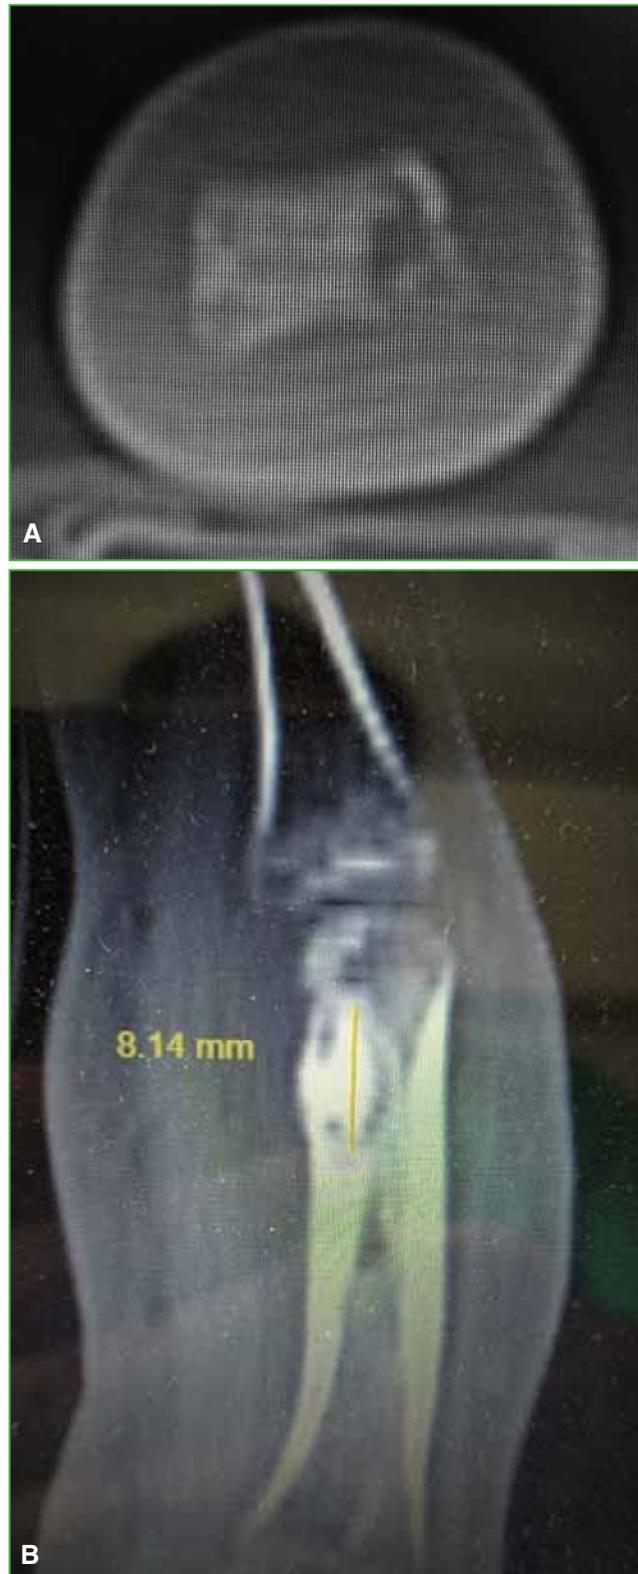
A. Case 2. Computed tomography. Notice the osteolytic image with central calcification associated with the nidus of the middle phalanx radial condyle. B. Case 4. Measuring of the lesion maximum diameter.
